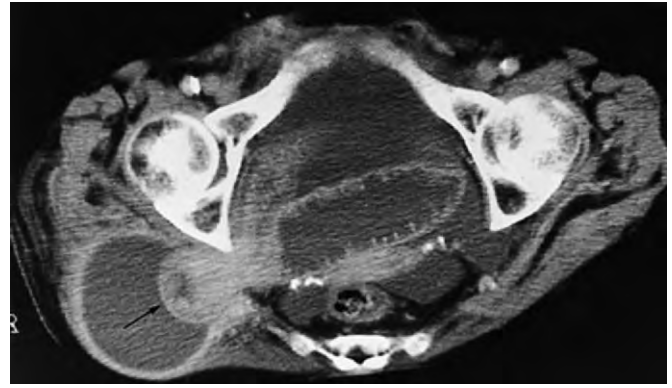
Computed tomographic scan showing incarcerated bowel (arrow) through the right sacral foramen and surrounding ascites in the right subgluteal region. (From Yu PC, Ko SF, Lee TY, et al: Small bowel obstruction due to incarcerated sciatic hernia: Ultrasound diagnosis. *Br J Radiol* 75:381, 2002.)
